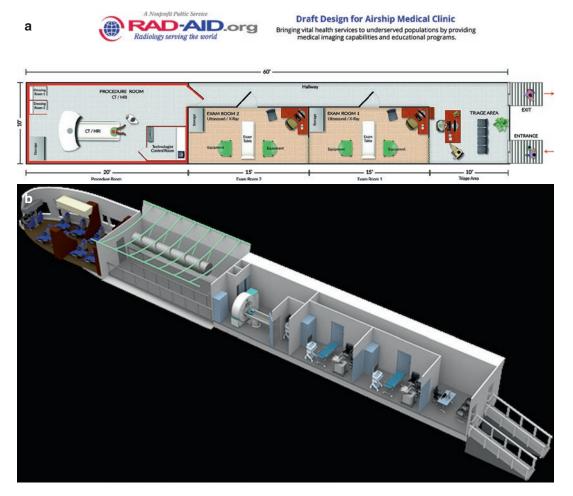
Draft design for RAD-AID's hybrid medical airship internal clinic with (a) floor plan and (b) 3D rendering highlighting CT scan and exam room capabilities
